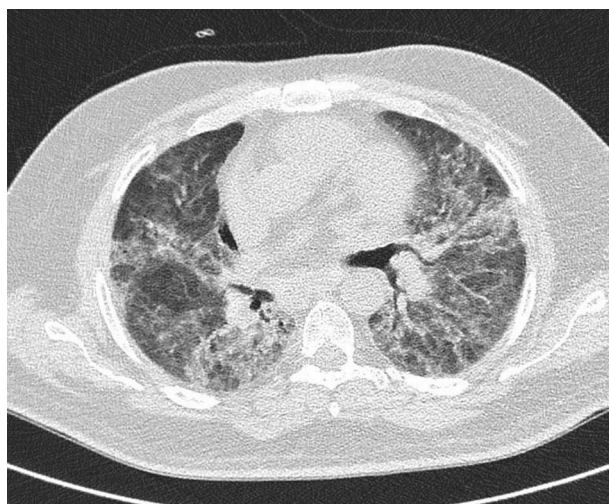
Thoracic CT scanner of the patient. The image is incompatible with a UIP pattern with an apical predominance and extensive ground-glass opacities.
